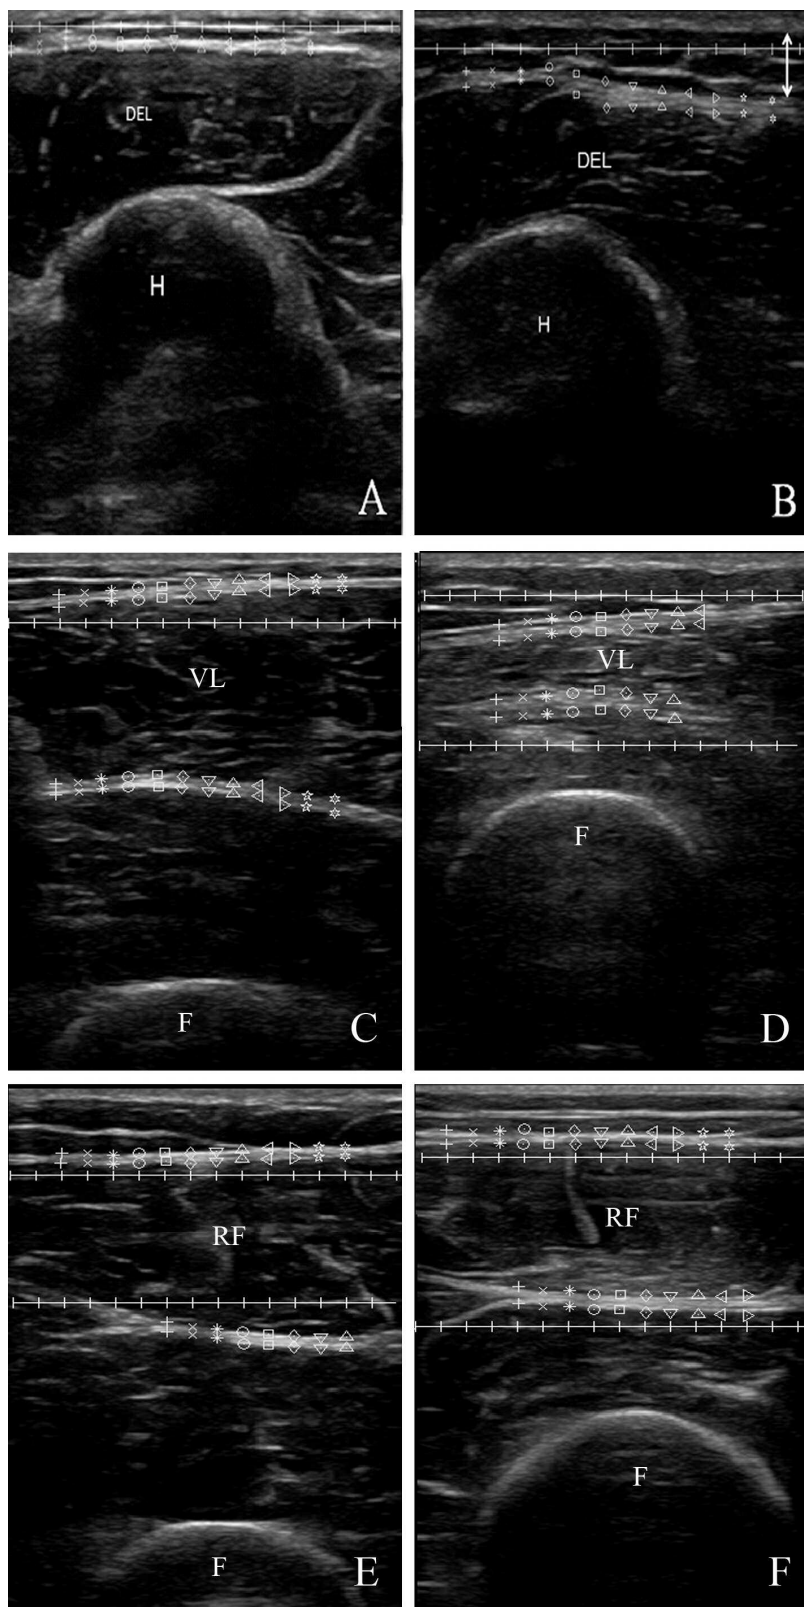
Transverse ultrasound images of deltoid (A, B), VL (C, D), and RF (E, F) muscles of a healthy person (left panels) and of 3 different patients with IIM (right panels). The calipers are placed around the superficial and deep fascia in these images. The fascia thickness of the DEL is clearly increased in the patient with IIM (9 SD above normal). The fascia thickening in this patient is not homogeneous, as can be seen from the placement of the calipers. The superficial and deep fasciae of the VL and RF are thickened (1.3 and 3.3 SD VL, 2.6 and 4.1 SD RF above normal, respectively), but less pronounced than the deltoid fascia. Double arrow in panel B indicates subcutaneous tissue. From Bhansing, *et al.* Muscle Nerve 2015;52:534-9; with permission². VL: vastus lateralis muscle; RF: rectus femoris muscle; IIM: idiopathic inflammatory myopathy; DEL: deltoid muscle; H: humerus; F: femur.
